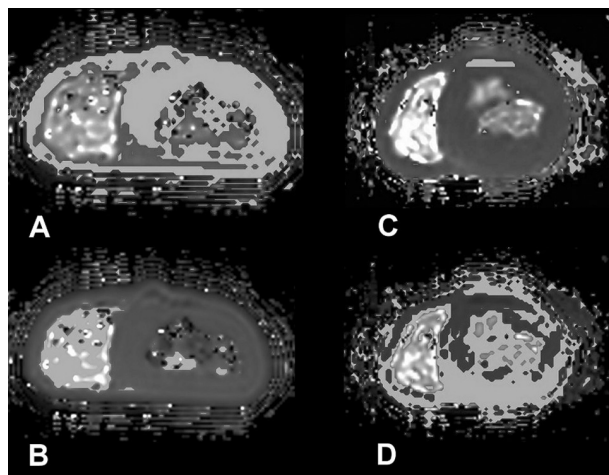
Short-axis T1-weighted MR images of hearts excised 5 hr following intrapericardial infusion of Gd-DTPA. (A, B): most of the myocardium, including the septum, has T1 values in the range of 600–900 msec (light gray areas of Panel A), consistent with the presence of Gd-DTPA throughout the tissue, rather than 1000–2000 msec (light gray areas, Panel B), indicating areas without Gd-DTPA. In the saline control heart, without Gd-DTPA, none of the myocardium has T1 values in the 600–900 msec range (light gray areas, Panel C) with most in the 1000–2000 msec range (light gray areas, Panel D).
